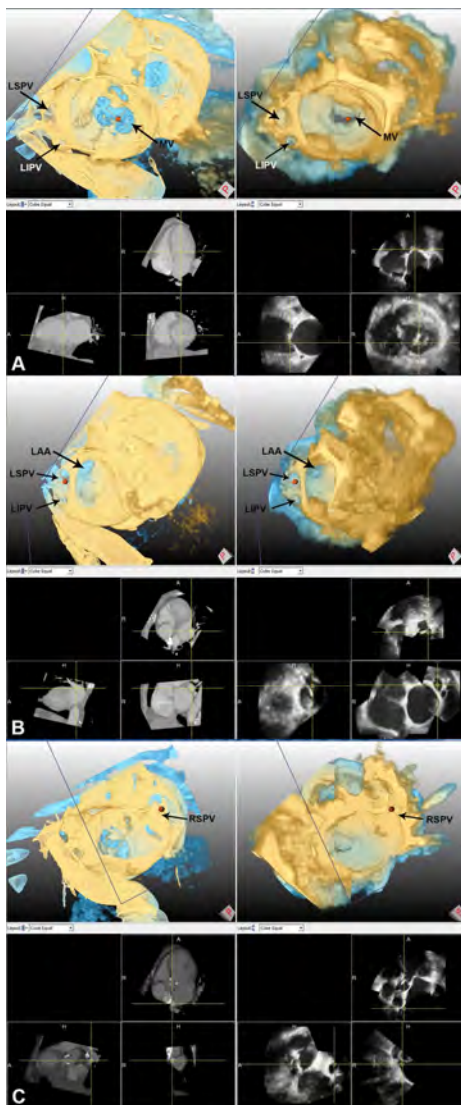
An example of a fused 3D transesophageal echocardiographic dataset and the corresponding CT dataset with important cardiac structures indicated. The 2D multiplanar reconstruction planes of both 3D echocardiographic and CT data are also shown. A: mitral valve en-face view with left pulmonary veins; B: left atrial appendage and left pulmonary veins; C: right inferior pulmonary vein. Some part of the fused 3D echocardiographic and CT datasets was cropped to reveal the anatomic landmarks. CT, computed tomography; LIPV, left inferior pulmonary vein; RSPV, right superior pulmonary vein; other abbreviations as in Figure 1.
